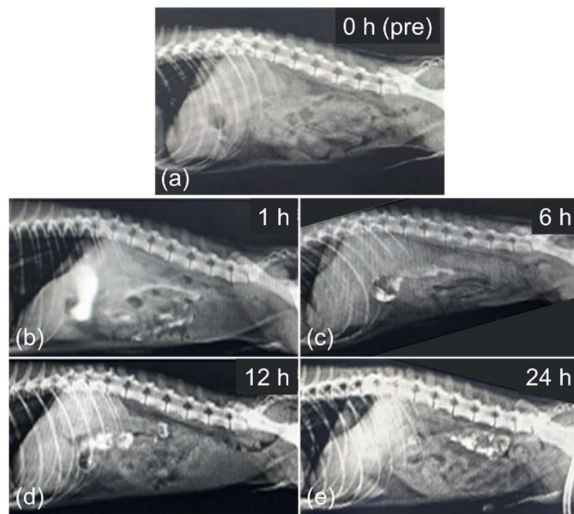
Preoperative abdominal radiography and serial contrast study. (a) Left lateral abdominal radiograph showing suspected small intestinal thickening and/or obstruction. Contrast radiographs were obtained at (b) 1 hour, (c) 6 hours, (d) 12 hours, and (e) 24 hours after contrast administration to evaluate gastrointestinal passage.
